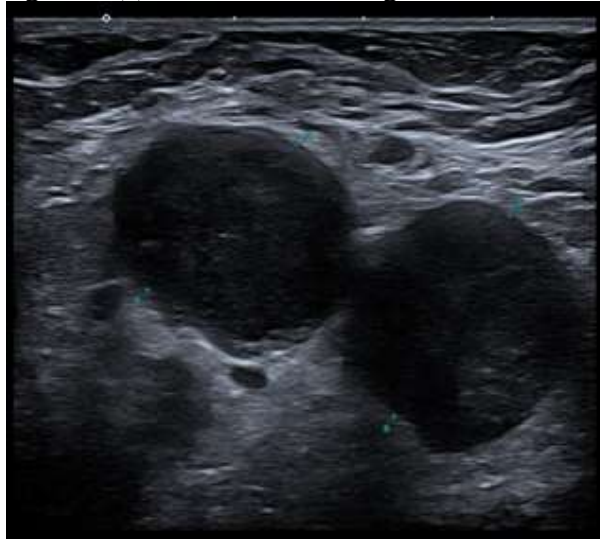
(b) Abnormal lymph nodes observed in the left axilla on ultrasound
